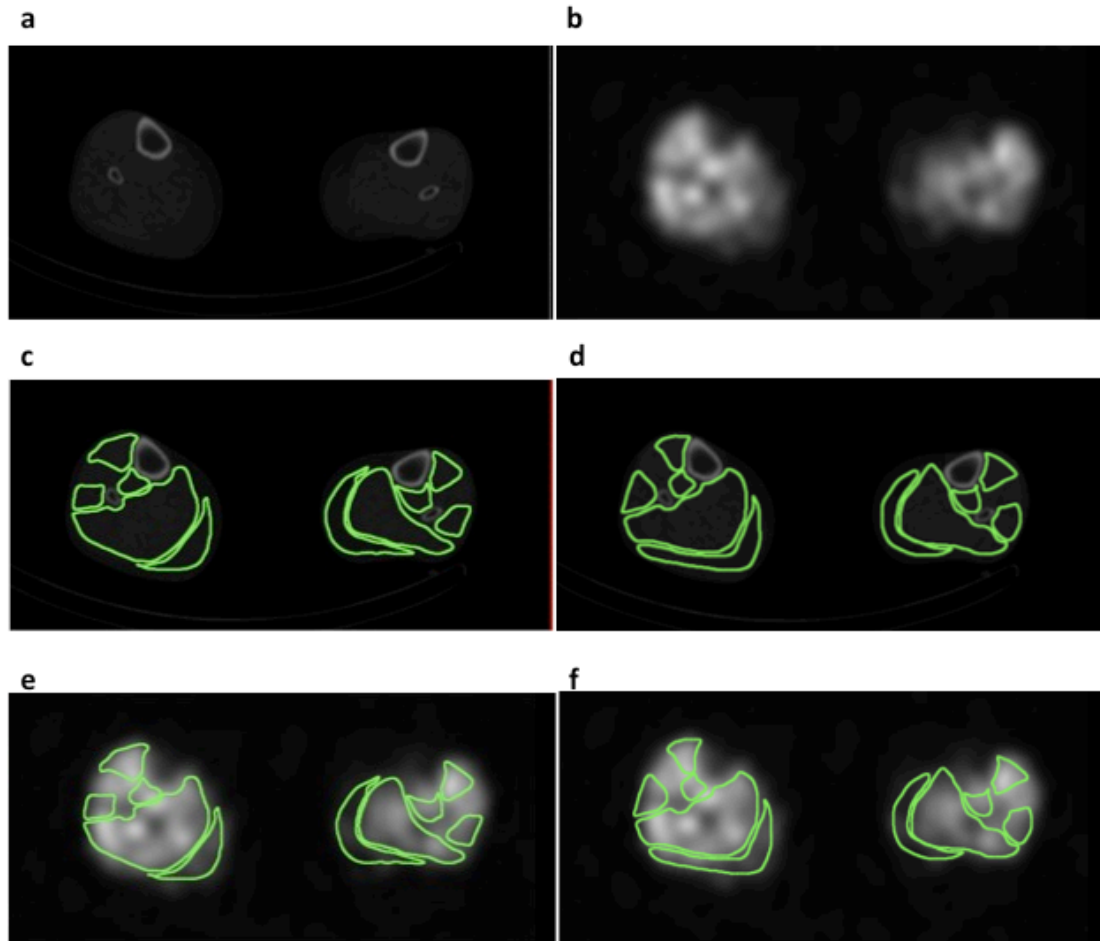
ROIs drawn on axial images of the calves of Patient E at rest. Panel a (CT image), b (SPECT image), c (CT image with first set of ROIs), d (CT image with second set of ROIs), e (SPECT image with ROIs copied from first set of ROIs), f (SPECT image with ROIs copied from second set of ROIs).
